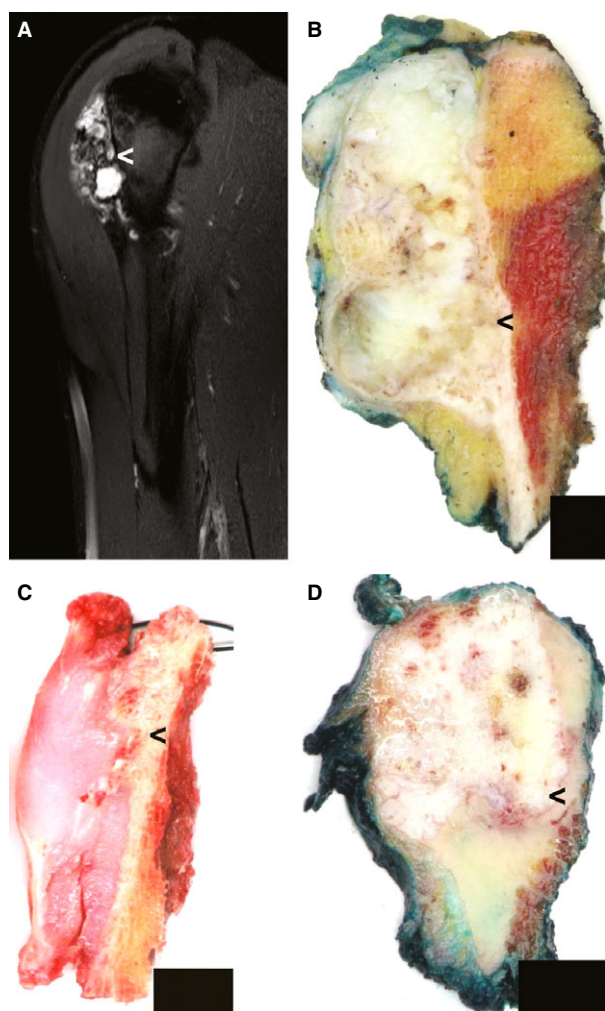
A, In the right proximal humeral metaphysis, there is a periosteally located large lobulated cartilage tumour (white arrowhead) with a maximum diameter of 55 mm, extending into the soft tissue (T1-weighted gadolinium magnetic resonance image). B, Macroscopic image of the periosteal cartilage tumour shown in (A). The black arrowhead indicates erosion of the cortex. C, D, Macroscopic image showing a periosteal lobulated cartilage tumour with erosion (C) and invasion (D) of cortical bone (black arrowhead). B, C, D, Black box from left to right = 10 mm.
